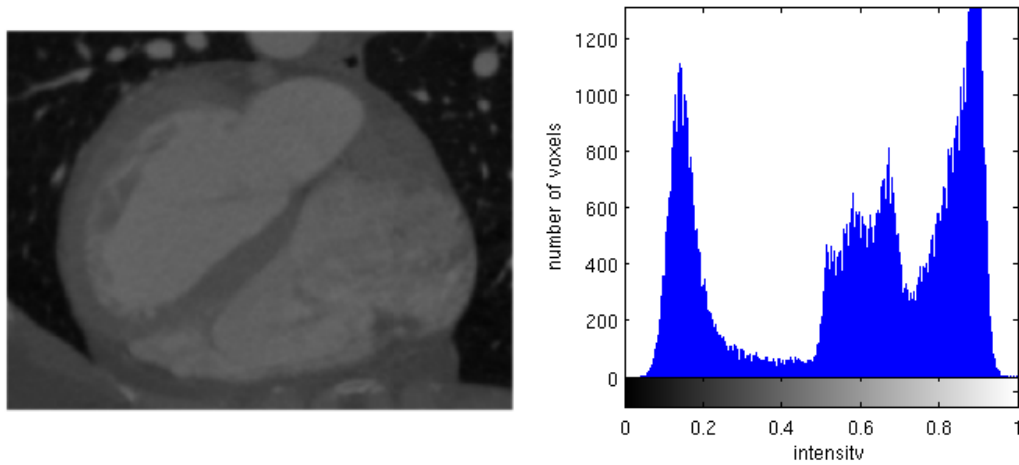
CTA image (left) and its histogram (right) before HE.
